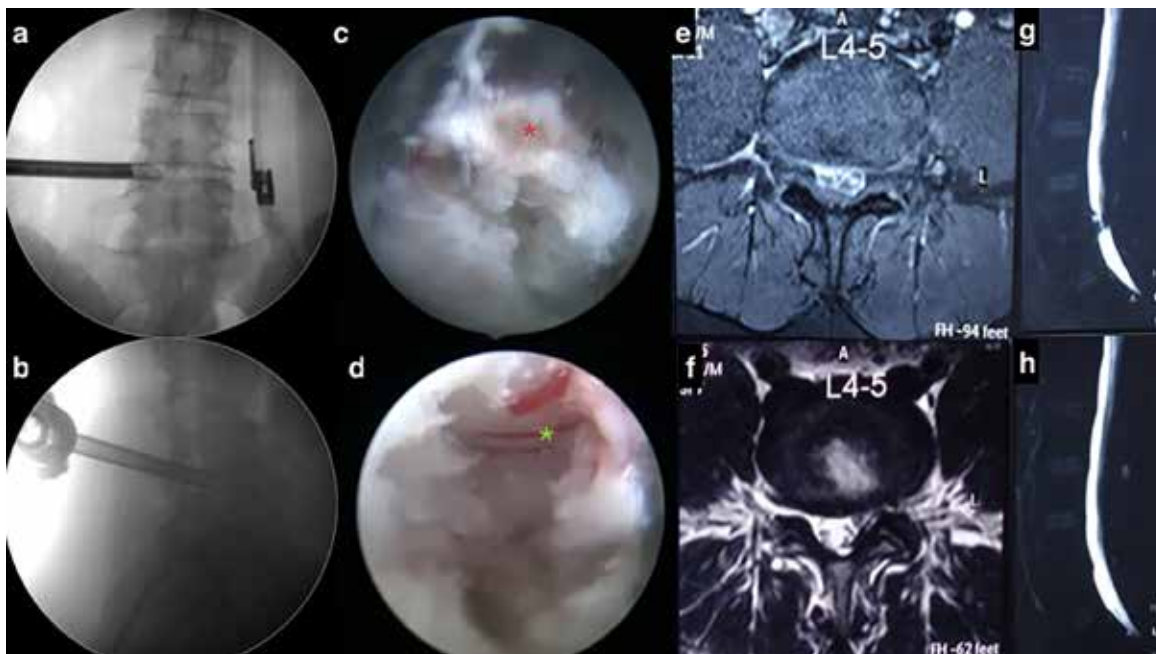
In the second patient (a,b) Paracentral location of endoscope & working channel combination in antero-posterior and lateral fluoroscopy. (c,d) After cutting the annulus the posterior longitudinal ligament and the cyst (red asterisk) protrude into the working channel. After complete crab-eating of the cyst, the decompressed dural sac and traversing root are visible (green asterisk). (e) Pre-operative contrast axial MRI demonstrating rim enhancement of multi-loculated cyst. (g) Pre-operative MR myelogram demonstrating a block at the same level. (f,h) postoperative MR imaging demonstrating removal of cyst and no block in the MR myelogram.
